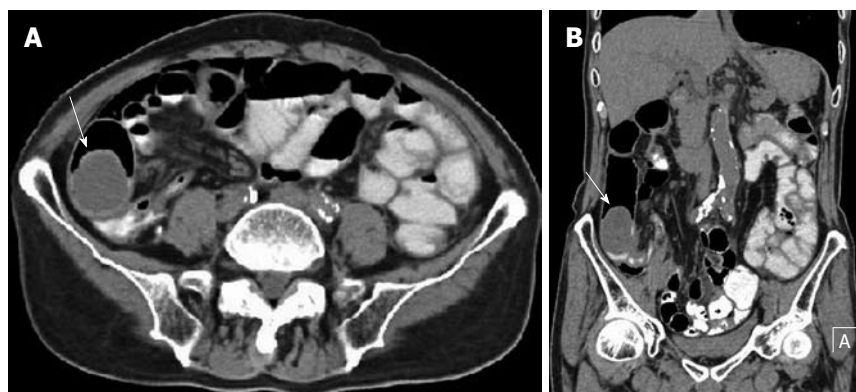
A 79-year-old male with ileum malignant fibrous histiocytoma, plain computed tomography scan abdomen. A, B: Axial (A) and coronal view (B) show intraluminal and intramural soft tissue mass of density 34 HU in the ileo-cecal region (arrows) without significant areas of necrosis. Note the oral contrast stagnation in the proximal loop of the small intestine and dilatation of the ascending colon.
